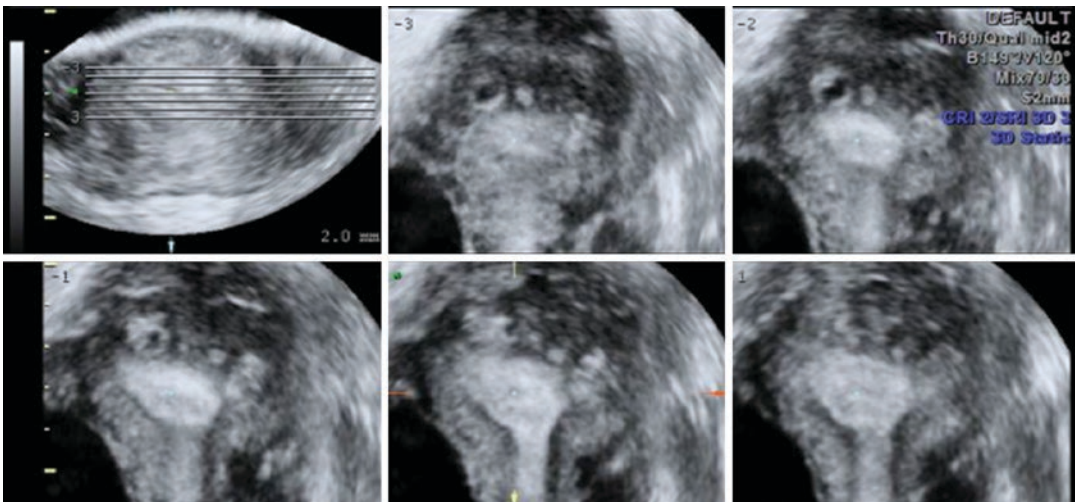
Ultrasound image of adenomyosis using VCI and TUI: irregular junctional zone
